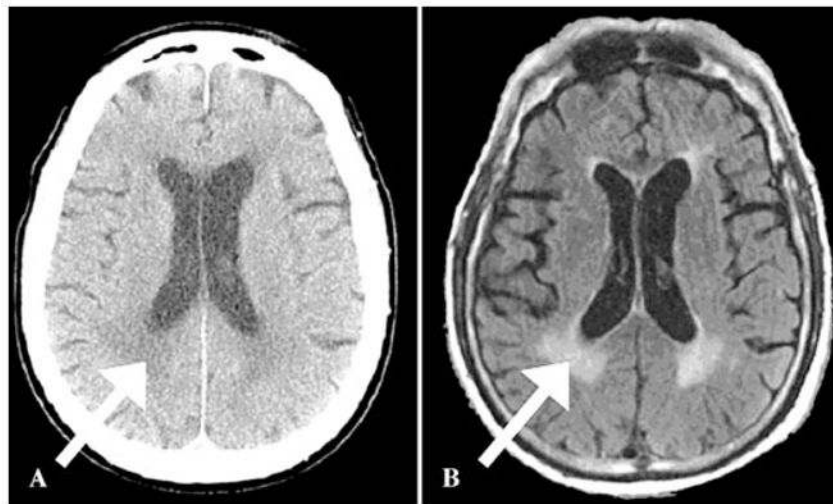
Leukoaraiosis is visible as (A) white matter hypodensity on CT and (B) white matter hyperintensity on FLAIR MRI in the same patient.
